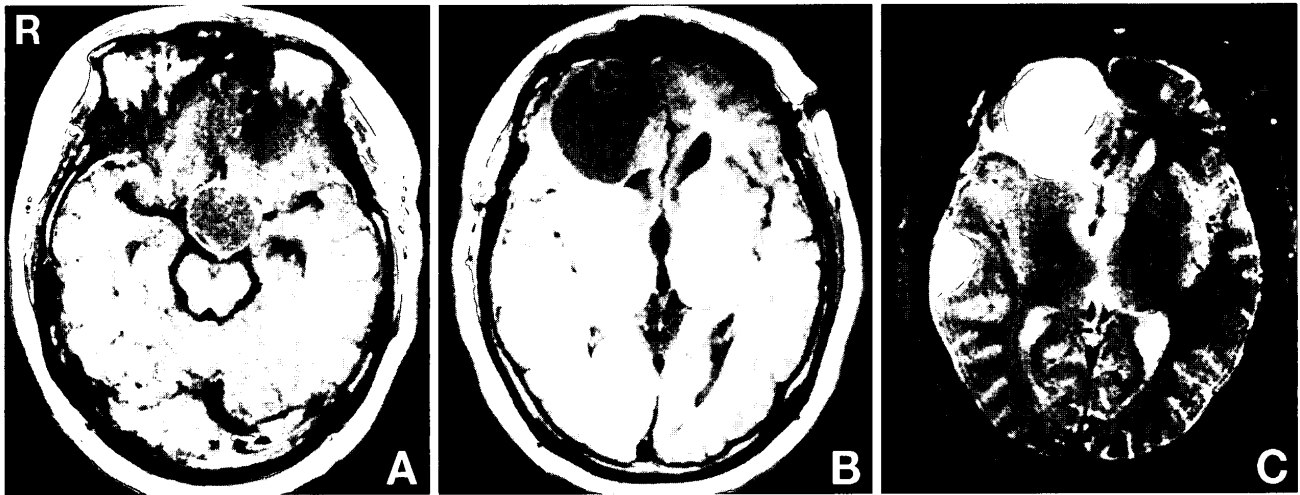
T₁-weighted magnetic resonance (MR) images with gadolinium (A, B) and T₂-weighted MR image (C) at the third admission showing the right frontal and temporal tumors in addition to the suprasellar tumor.
